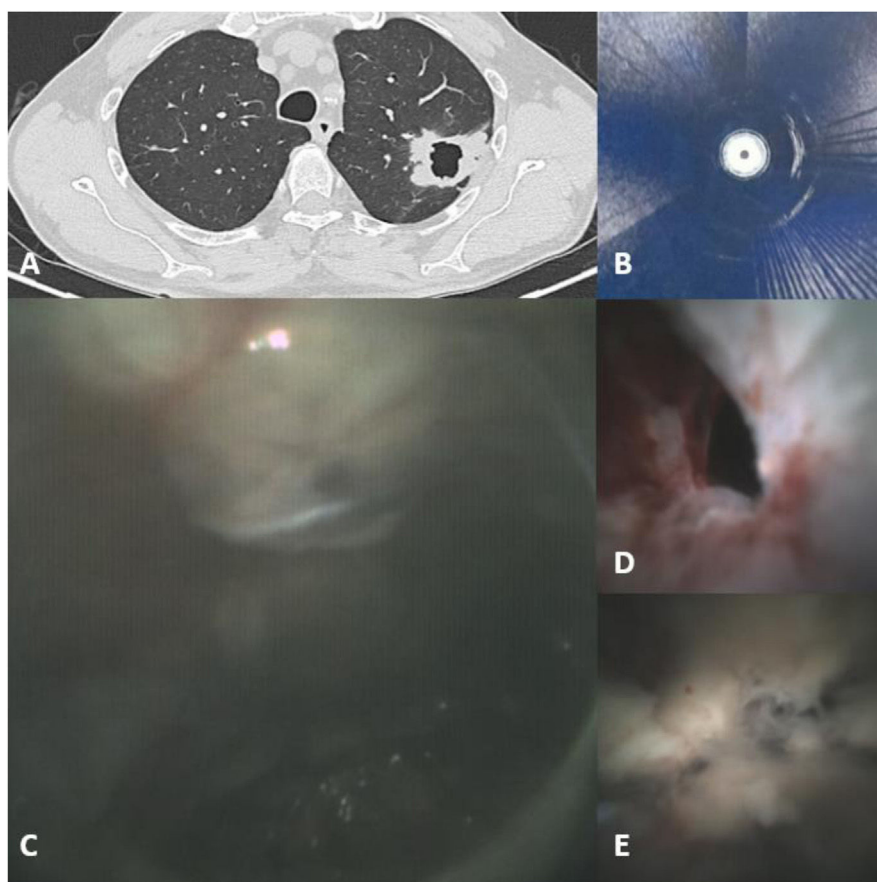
Left upper lobe cavitory lesion. (A) Chest CT. (B) Radial endobronchial ultrasound revealed no detectable image. (C) Iriscope® view of the cavity. (D) Iriscope® view of the cavity entrance. (E) Iriscope® view of a pathological area inside the cavity, with “fish flesh” aspect.
